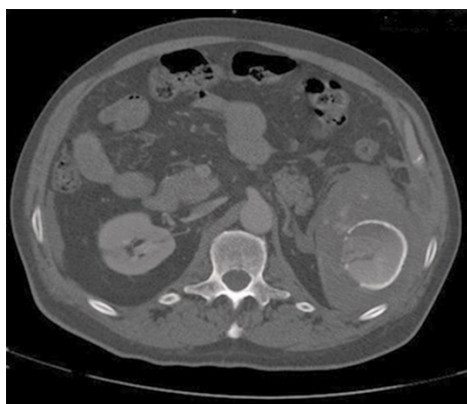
CT scan showing splenic laceration with intra-abdominal hemorrhage and ruptured hydatid cyst.
